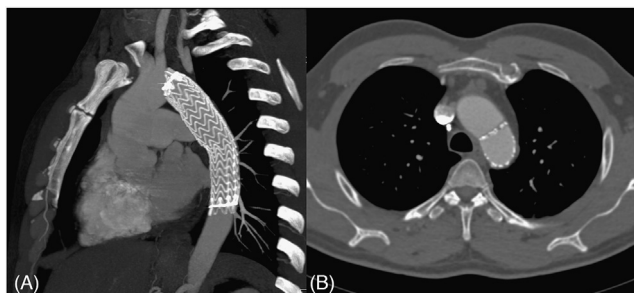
Computed tomographic angiography showing proximal dislocation and near closure of the stent graft. (A) Axial view. (B) Maximum intensity projection sagittal view.
